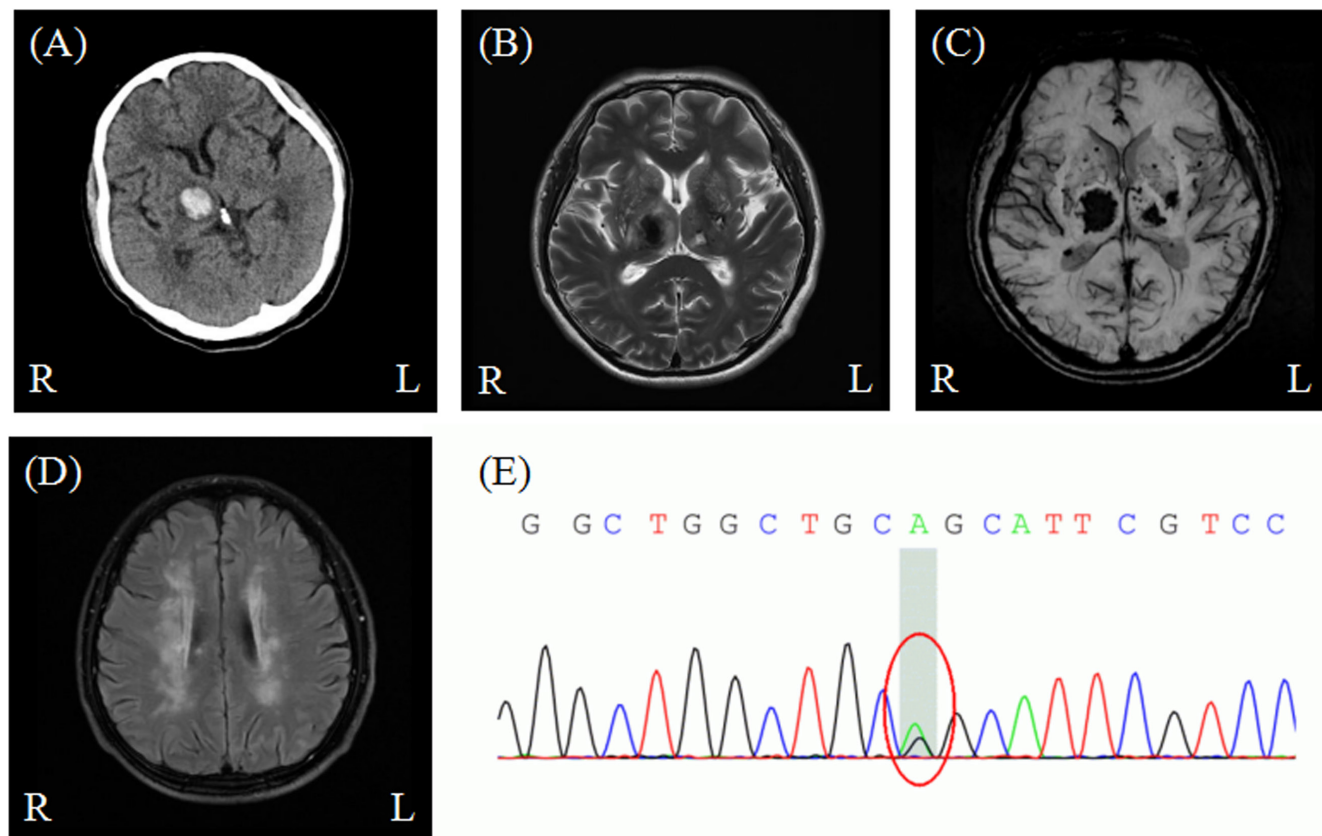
Brain image exam and genotype results. (A) CT scan reveals acute hemorrhage of the right thalamus; (B) T2-weighted MR imaging showed low signal in the right thalamus and high signals in the left thalamus and the posterior limb of the internal capsule, suggesting that the right thalamus was an acute cerebral hemorrhage, and the left thalamus and the posterior limb of the internal capsule were old cerebral hemorrhage lesions; (C) SWI revealing multiple intracranial hemorrhages and microbleeds; (D) Severe diffuse leukoencephalopathy in deep white matter; (E) Sequence the heterozygous mutation c.1759C>T in exon 11 of the *NOTCH3* gene.
